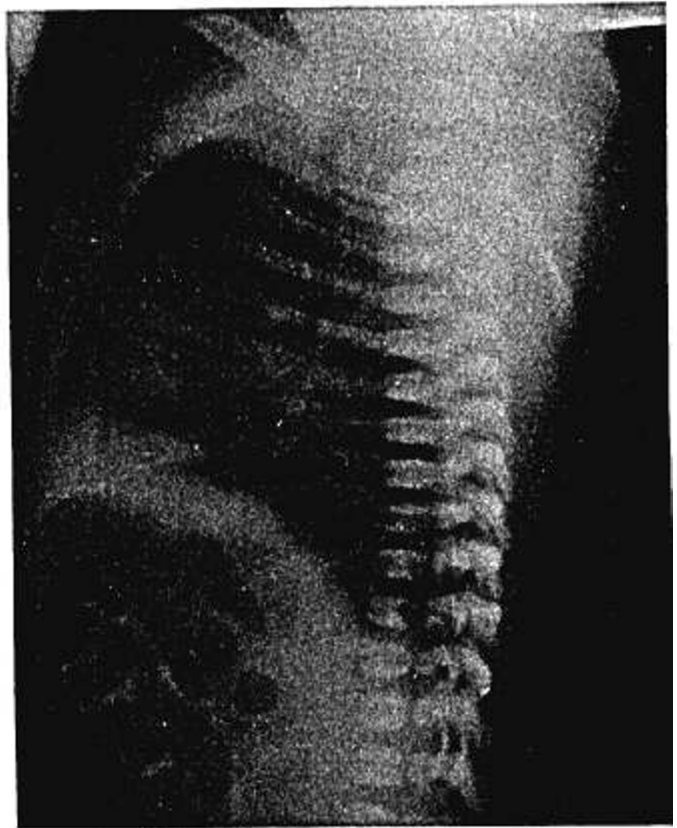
Chest x-ray of severe combined immune deficiency patient taken at birth shows no thymic shadow.
